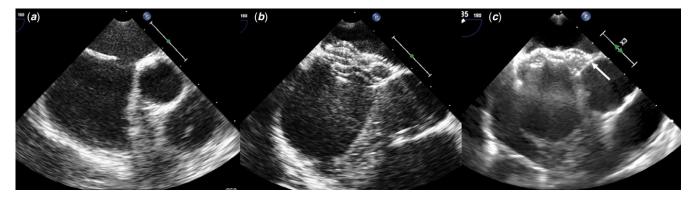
Description of the patient with cardiac erosion by an Amplatzer septal occluder. This was a 14-year-old patient, weighing 43 kg with an atrial septal defect size of 11 mm. (a) There was good, solid around the atrial septal defect except for the aortic rim. The aortic rim was completely devoid of tissue. (b) A 14 mm Amplatzer septal occluder was implanted without difficulty. However, the pre-discharge echocardiogram showed the device abutting the aortic root. (c) On day 3 post-procedure, there was large hemopericardium detected on echocardiogram. The patient underwent emergency surgery to remove the septal occluder and closure of the atrial septal defect. Intraoperative, the device was seen eroding through the roof of the atrium just posterior to the aortic root.
